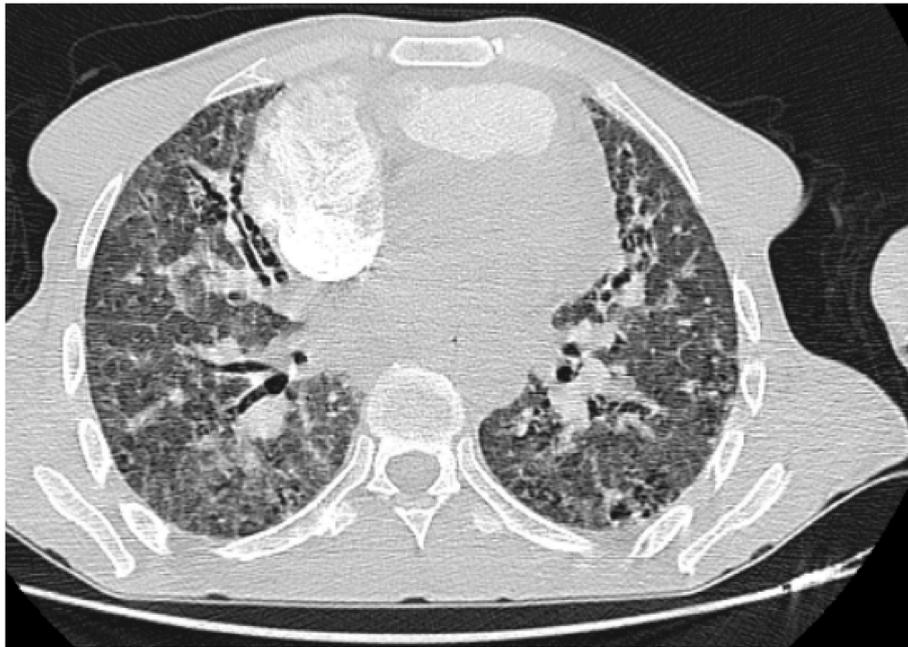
A 55-year-old man follow-up contrast-enhanced axial chest CT image in lung window, 5 months following initial presentation, showing extensive residual pulmonary ground glass opacities (23 CT severity score), and traction bronchiectasis.
